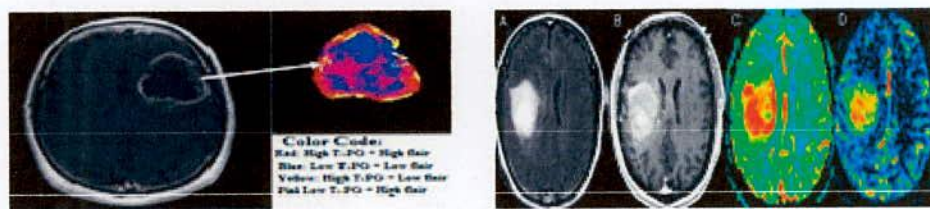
Color coded ANN based segmentation (left side) and example of ANN based brain MRI image segmentation (right side)
